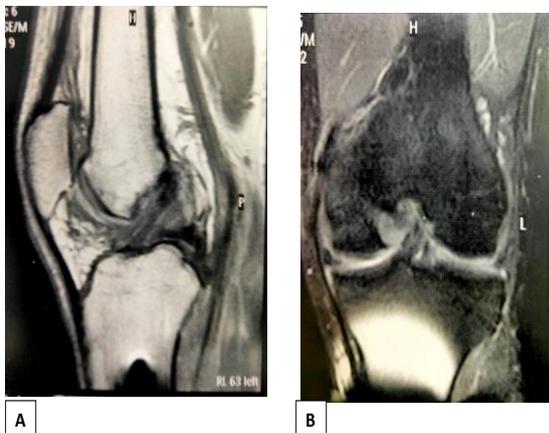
a) Sagittal PD and (b) Coronal GRE MR images in a show partial disruption of ACL graft, increase SI within the graft
